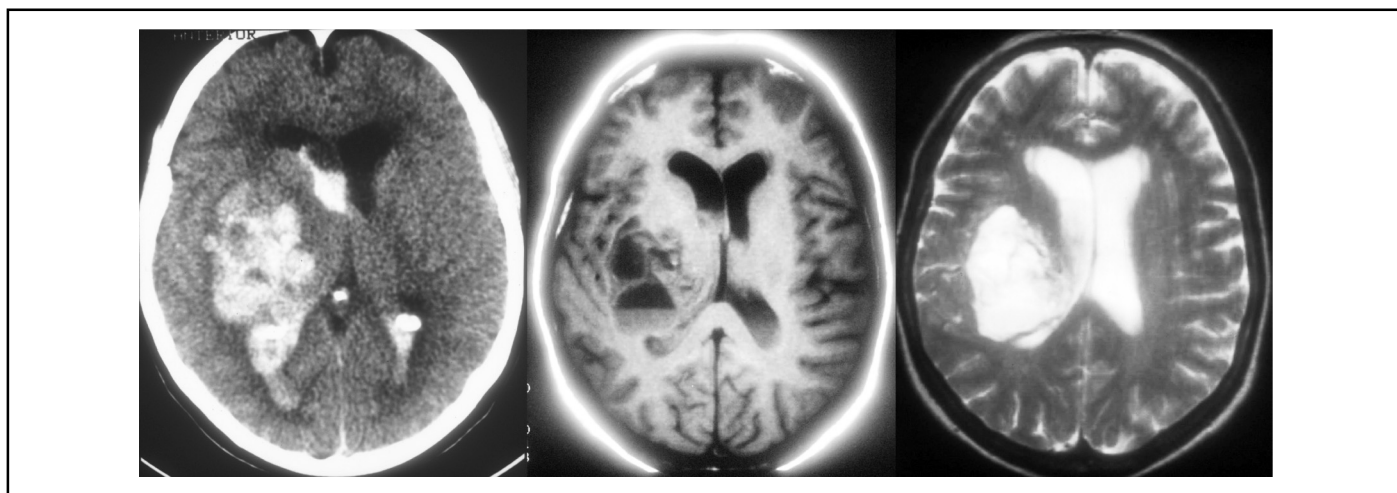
(4a to 4c) CT, T1 and T2 show acute intracranial hemorrhages in the right putamen and thalamus, which appear T1 hypo and T2 hyperintense lesions due to oxyhemoglobin in the hematoma.
